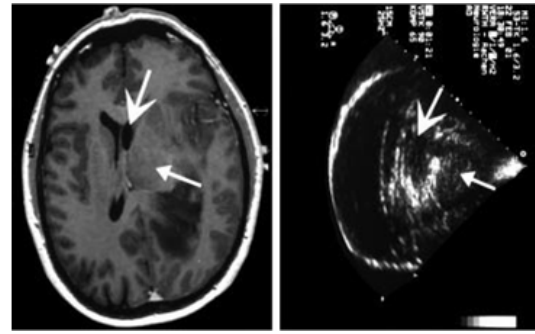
Ultrasound scan (right) of a cerebral tumour (small arrow) located near the lateral ventricle (large ventricle) [Harrer *et al.*, 2003]. Magnetic resonance scan of the tumour for comparison (left).
